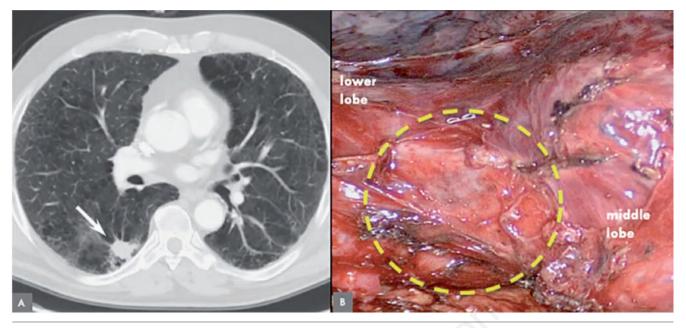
A) Chest computed tomography (CT) scan showing lung cancer in the right lower lobe (white arrow). B) Adventitial fibrosis of the right lower lobe artery (dashed yellow circle highlights the area) encountered during the dissection of the major fissure.
